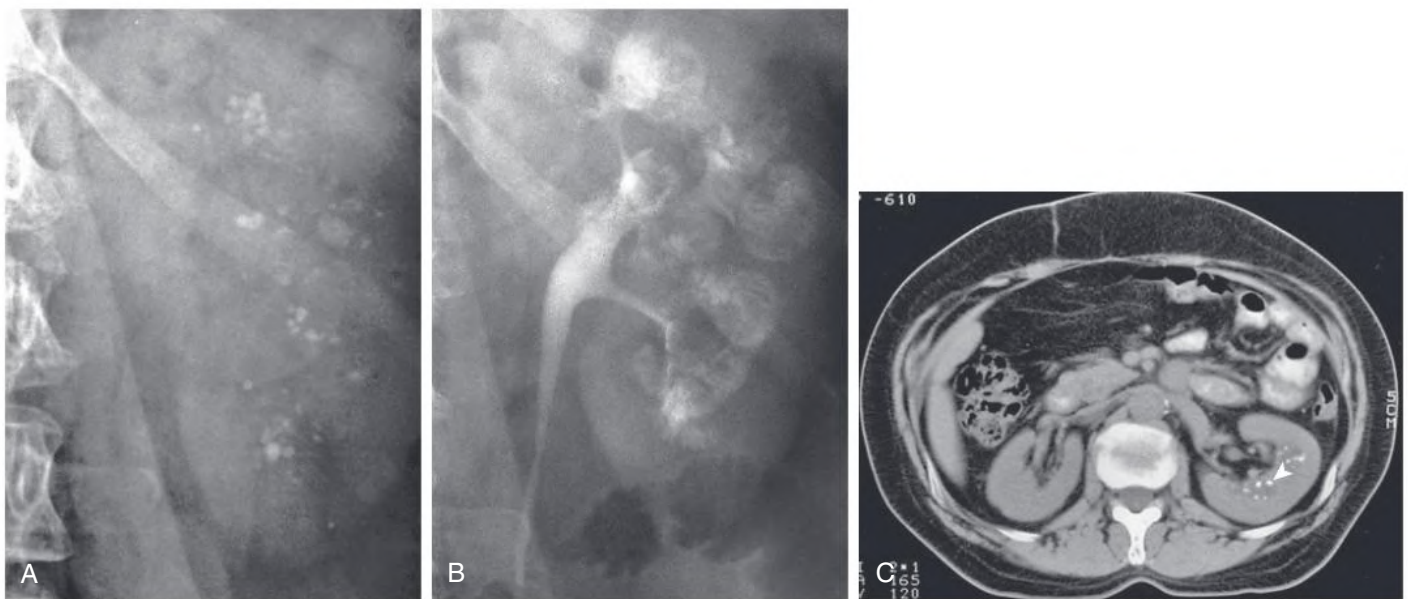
Radiologic Findings Associated With Medullary Sponge Kidney. (A) Preliminary radiograph shows medullary nephrolithiasis. (B) Initial radiograph from excretory urography shows clusters of rounded densities in the papillae among discrete linear opacities (paintbrush appearance). (C) Nonenhanced computed tomography reveals densely echogenic foci in the medulla (arrowhead).
